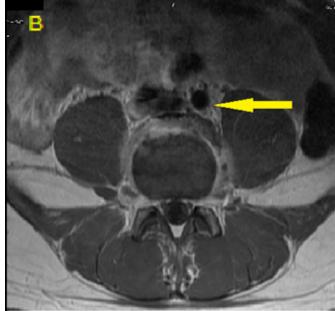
Magnetic resonance imaging scan showing (A) sagittal, and (B) axial sections of the lumbar spine with 15 cc of ProHance. The disc spaces does not show any narrowing while L4/L5 junction shows morrow edema with enhancement of anterior endplates and thickening of anterior longitudinal ligament; overall picture is suggestive of disc sparing infectious spondylitis.
